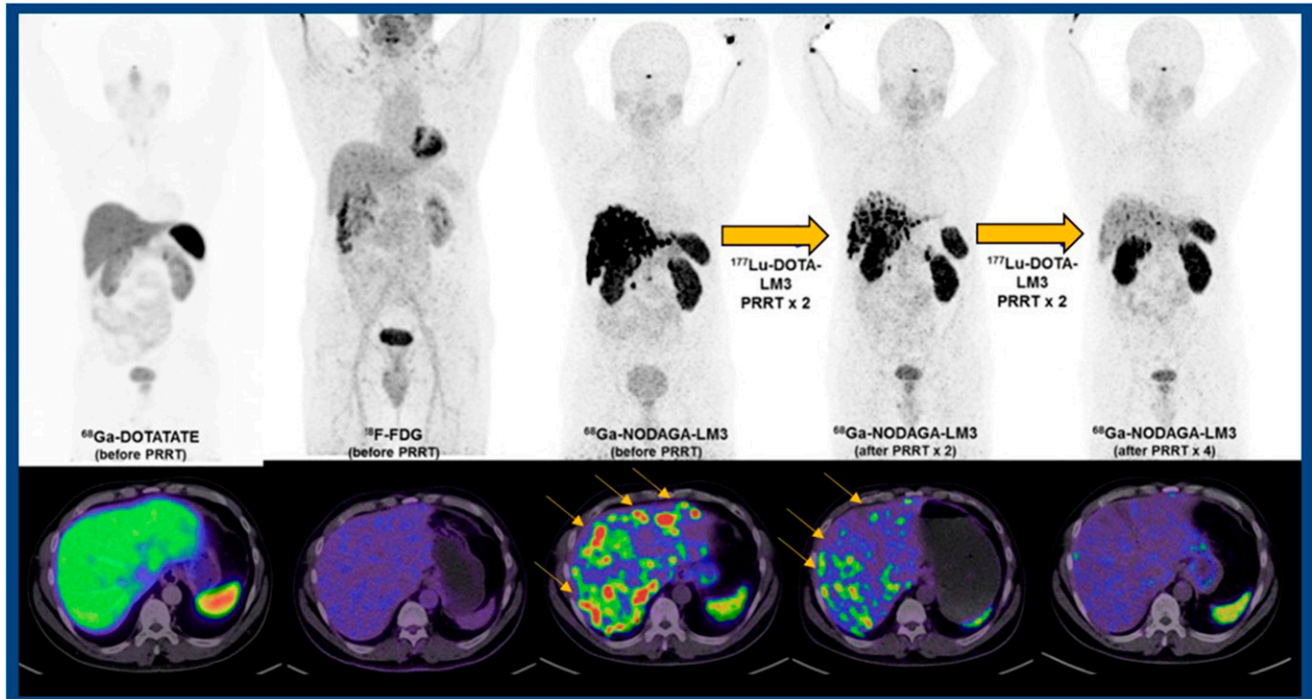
First-in-human study of novel somatostatin-receptor (SSTR) antagonist ^{177}Lu -DOTA-LM3 for peptide-receptor radionuclide therapy (PRRT) in patients with advanced metastatic neuroendocrine neoplasms and low SSTR agonist binding. Example images in a patient imaged (left to right): with ^{68}Ga -DOTATATE and ^{18}F -FDG before PRRT and with ^{68}Ga -NODAGA-LM3 before, after 2 cycles, and after 4 cycles of ^{177}Lu -DOTA-LM3 treatment.
